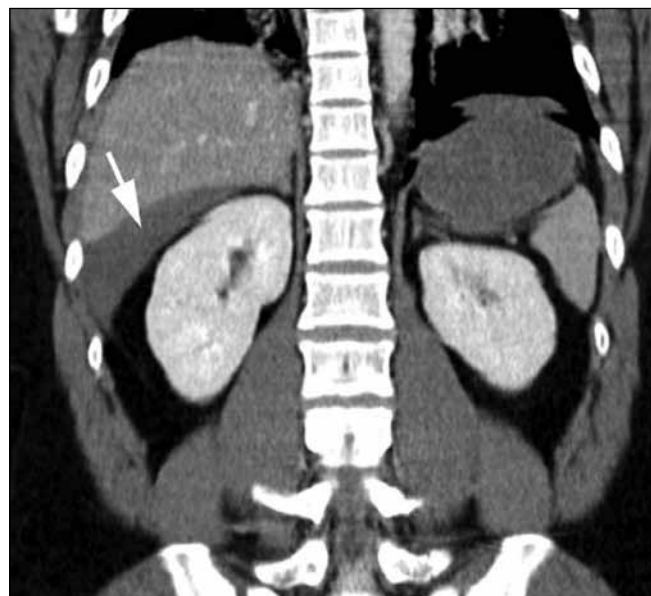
CT oblique coronal reformat of the same patient whose images appear in Figs 3 and 4 shows free fluid in the hepatorenal recess (white arrow) with free fluid surrounding the liver.
